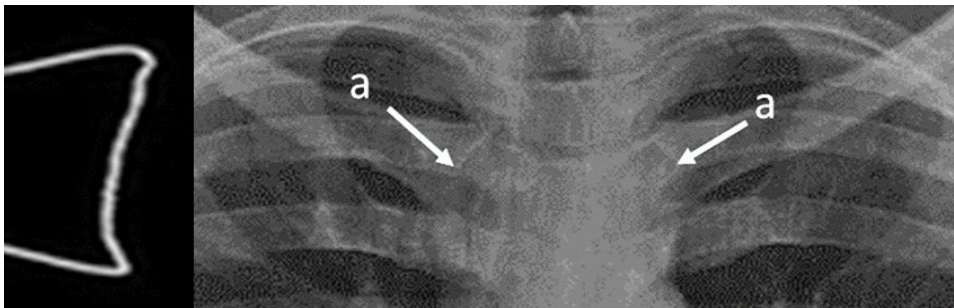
Radiograph of a 16-year-old patient showing stage 1 ossification: the estimated age = 15 years. a — curved medial epiphysis.
